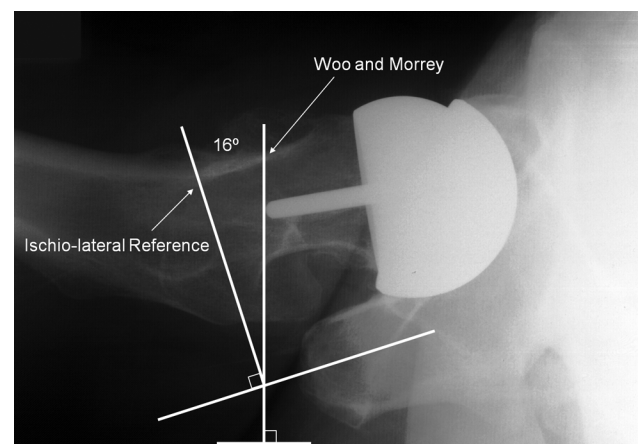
Danelius-Miller¹⁶ lateral radiograph showing the external reference used by Woo and Morrey,⁶ which is a line perpendicular to the horizontal film edge. A line perpendicular to the long axis of the ischial tuberosity is also drawn, demonstrating the ischio-lateral skeletal reference. The measured difference between these references in this example is 16° .
